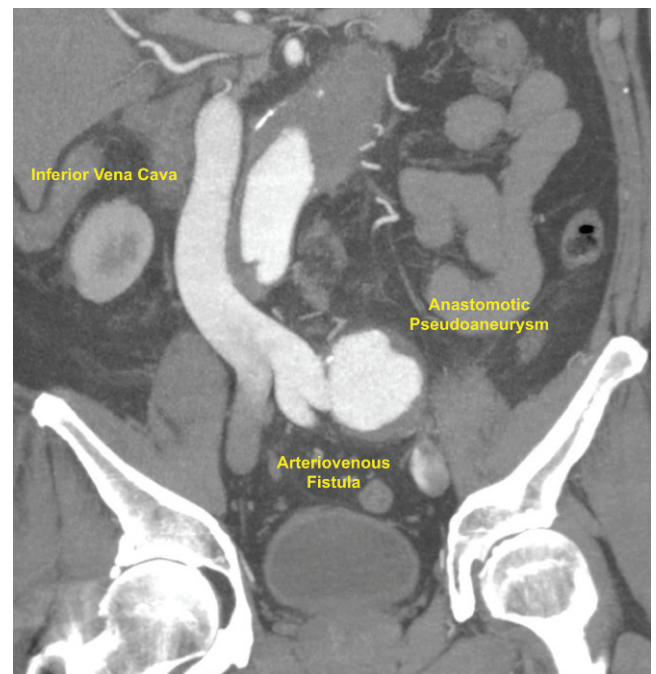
Contrast-enhanced computed tomography angiography (CTA), showing the anastomotic pseudoaneurysm and the ilio-iliac arteriovenous fistula. The inferior vena cava is fully contrasted, indicating an arteriovenous fistula.
